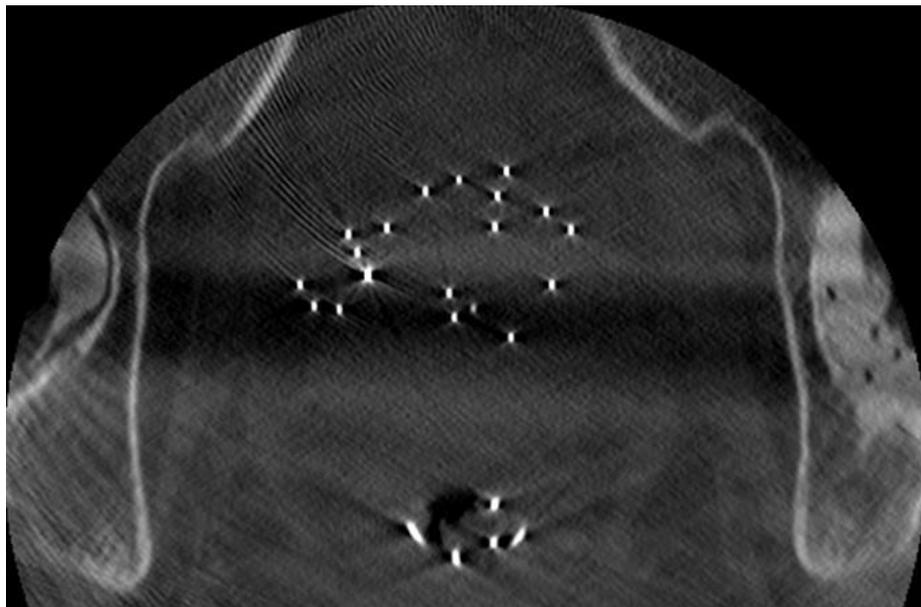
CT slice from 7th bilateral hip patient at SCGH (GE Lightspeed VCT, 140 keV, auto mAs. FOV 150x150 mm, 512x512 array, 16 bit grey-scale, 0.625 mm slice thickness, ‘bone’ filter). Needle markers and wire ribbon in rectal packing are visible. One implanted fiducial marker shows as brighter spot near image centre.
